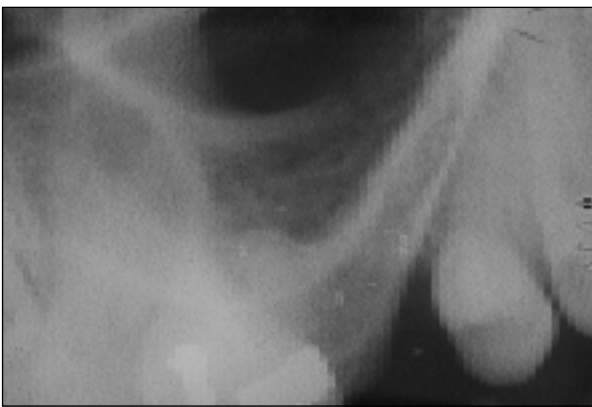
Periapical radiograph showing insufficient alveolar bone for a single-tooth implant in area of the second premolar.
